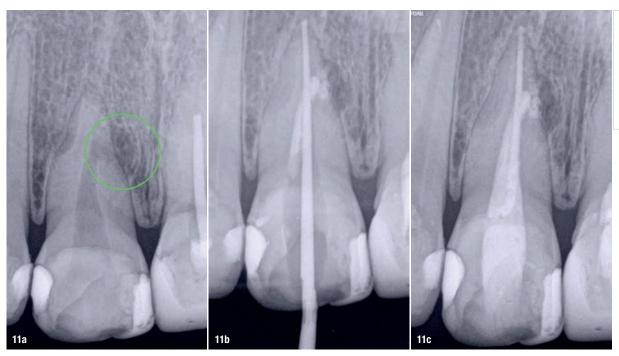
Video of sonically activated placement of a calcium silicate-based endodontic sealer (https://youtu.be/CmXNk2uh6Mw). Figs. 11a-c: Radiographic sequence of the treatment performed in tooth #11. Initial radiograph. The root resorption and lateral radiolucent area were evident (a). Master cone fitting at the level of the complete working length (b). Completed root canal therapy (c).
